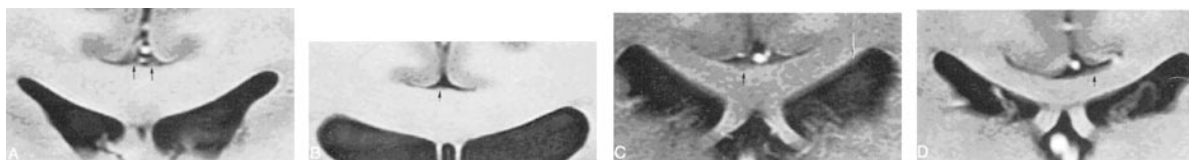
Representative MR images of the IG classical, symmetric two-strip (A), symmetric, but centrally fused (B), lateralized, single-strip (C), and thin-layer (D) patterns.
